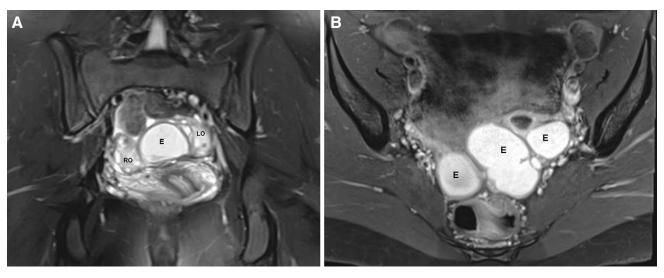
Coronal T2 weighted MRI image with fat saturation (A) in an adolescent female with endometriosis reveals medialization of the right (RO) and left (LO) ovaries, which are adherent in the midline with an intervening T2 hyperintense
